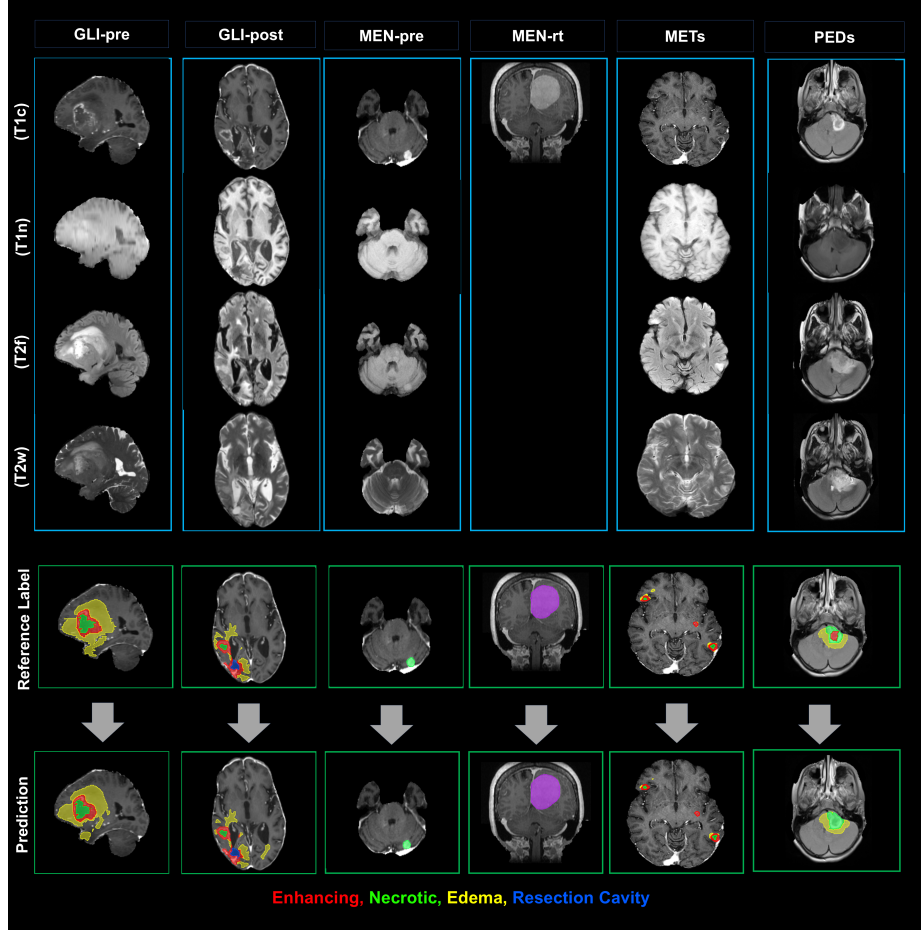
Overview of studied segmentation tasks. Each column delineates a specific segmentation task, while the upper four rows indicate the corresponding MRI modalities required. Tumor subregions, including *ET*, *NETC*, *SNFH*, *RC*, *CC* and *GTV*, are depicted with distinct color-coded segmentation labels superimposed on representative 2D slices.
